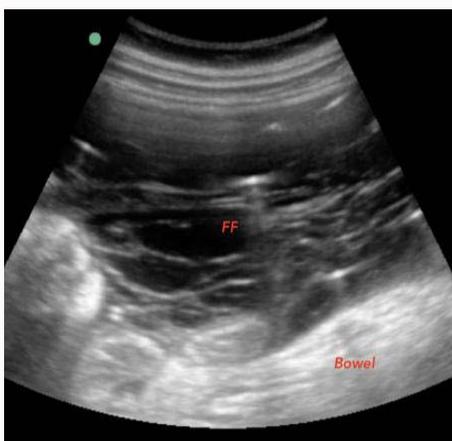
Transabdominal ultrasound of the right upper quadrant showing free fluid with lacelike internal echoes and bowel present in the bottom right of the image (FF: Free Fluid).
